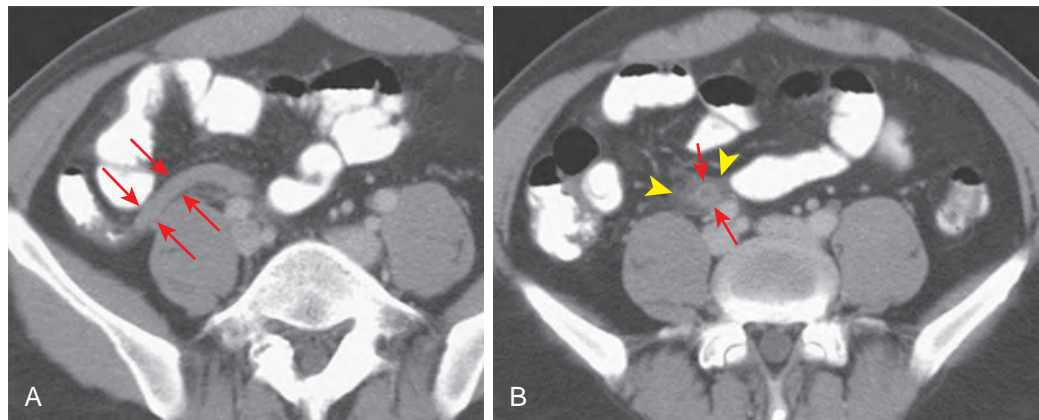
Distal or tip appendicitis. A. The proximal appendix (arrows) is normal in appearance on this enhanced CT scan. B. The distal aspect of the appendix demonstrates abnormal mural thickening and enhancement (arrows); periappendiceal soft tissue stranding is also present (arrowheads).
